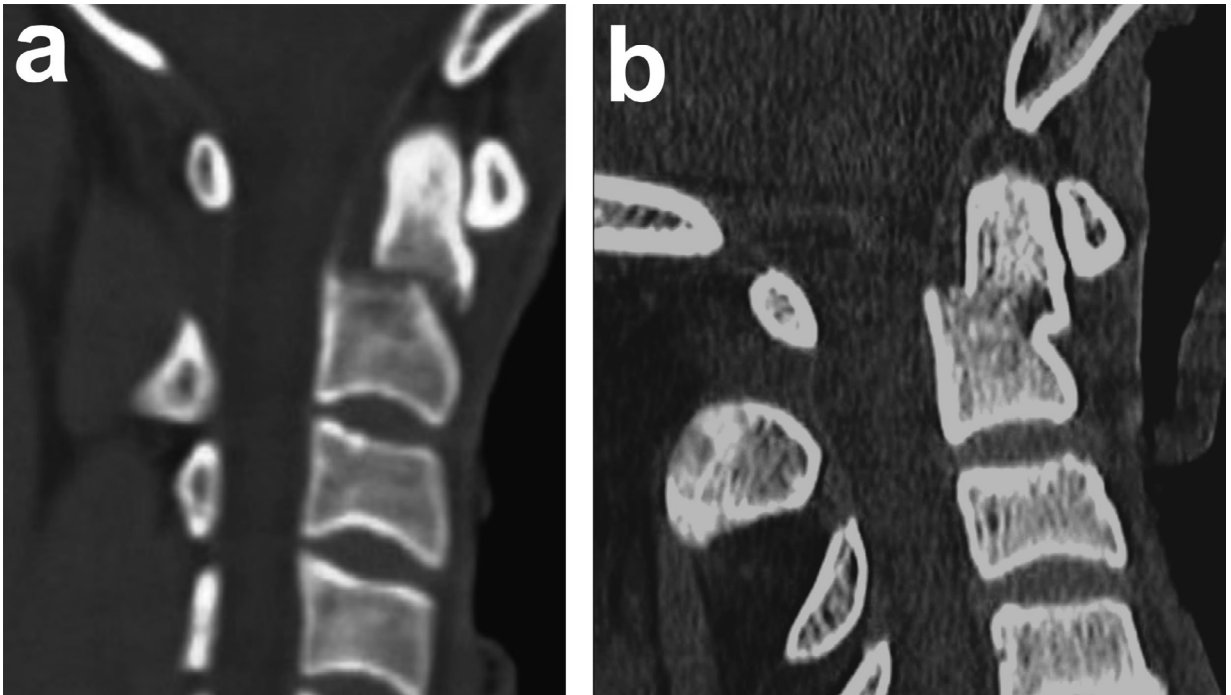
a) Anteriorly displaced type II odontoid fracture on a sagittal cervical CT scan, b) CT sagittal view shows odontoid union at 7 weeks after Minerva CTJ application.
